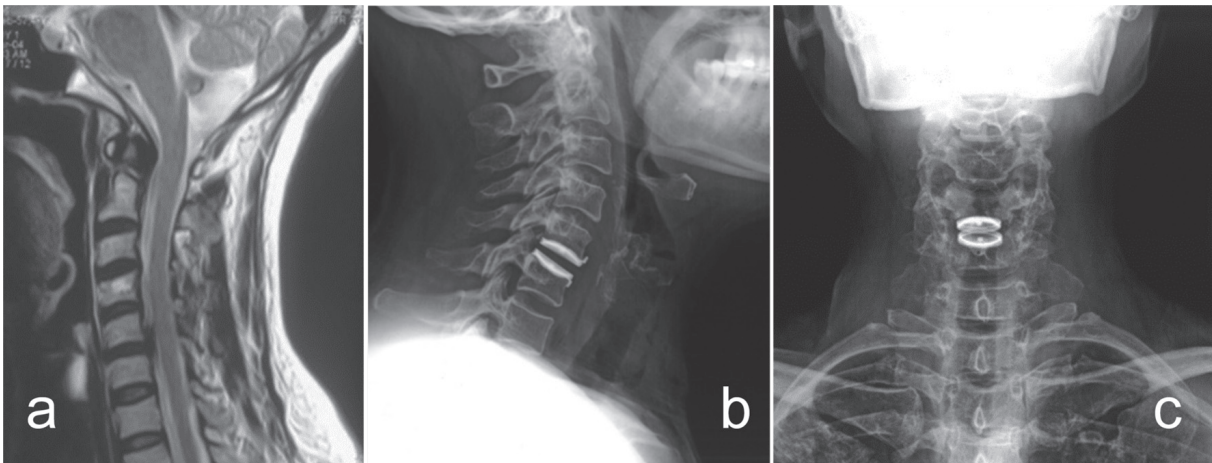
Preoperative MRI (a) and postoperative x-rays (b, c) of a patient with Bryan disc prosthesis.
